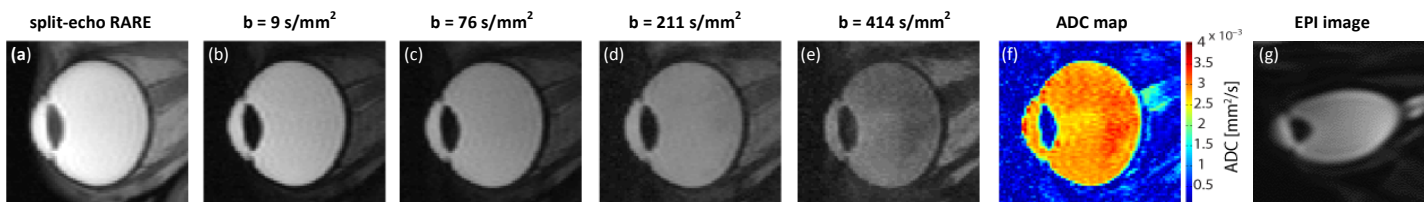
DWI of the eye at 3 T. (a) Split-echo RARE image of the eye serving as a reference. (b)-(e) Diffusion weighted images of the eye obtained with segmented DWI-RARE using b-values ranging from 9 s/mm^2 to 414 s/mm^2 . (f) ADC map calculated from the diffusion weighted images. (g) EPI image ($b = 0 \text{ s/mm}^2$). Please note the severe distortion.
